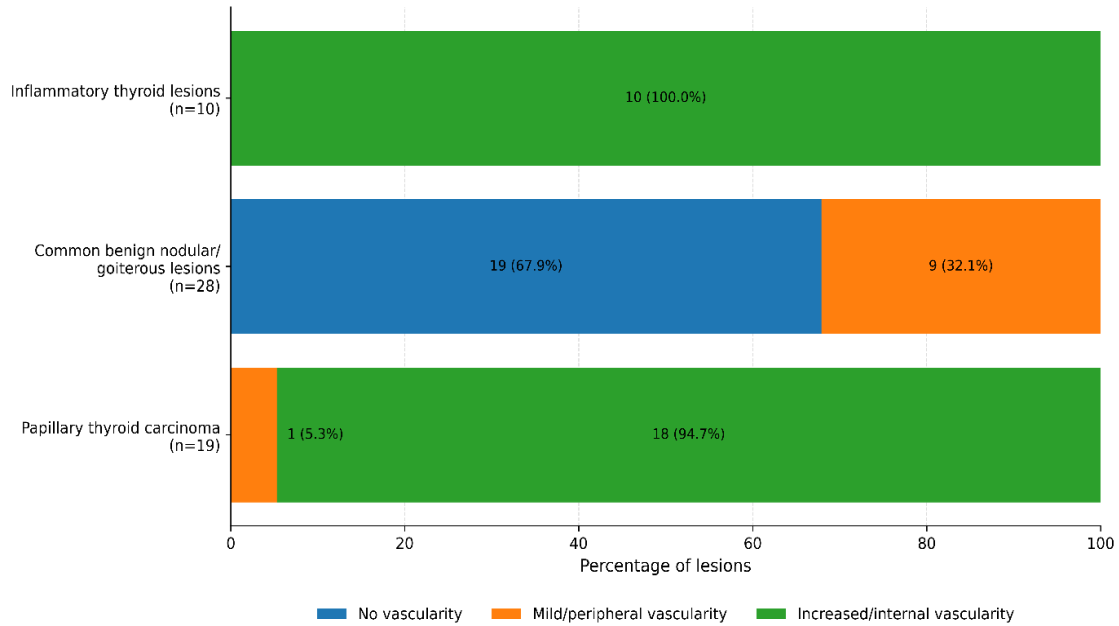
Distribution of Doppler vascularity in papillary thyroid carcinoma.
